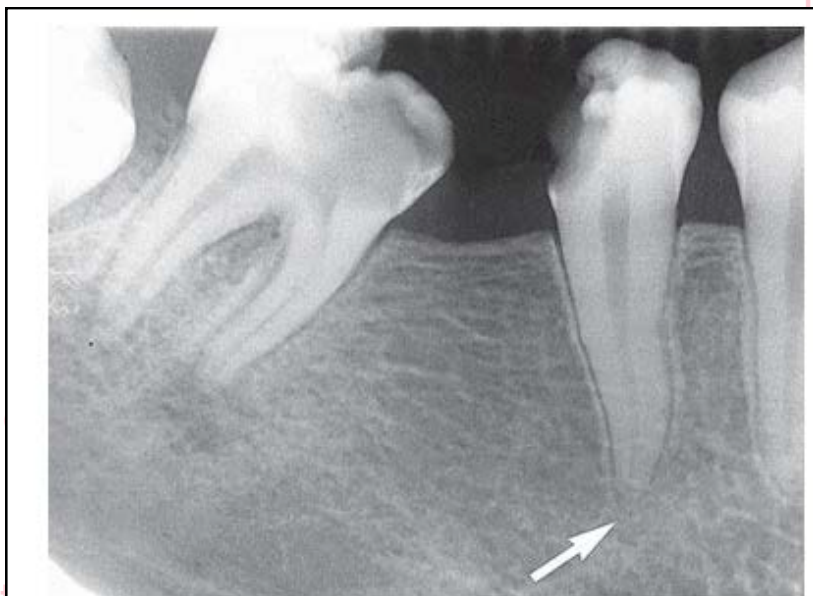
A very early lesion involving the pulp of the second bicuspid without significant change in the periapical bone (*arrow*). In contrast, note the loss of the lamina dura and periapical bone at the apex of the mesial root of the second molar. Also note the subtle halo of sclerotic bone reaction around this apical radiolucency.
